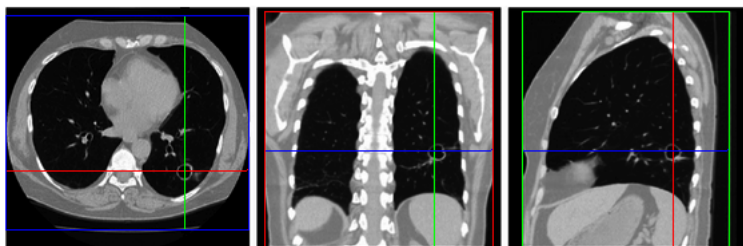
Axial (blue), coronal (red) and sagittal (green) sections of a CT scan showing lungs. Credit : [6]. Colored lines show the links between each views, i.e. the coronal view corresponds the slices shown in red in the other sections.
